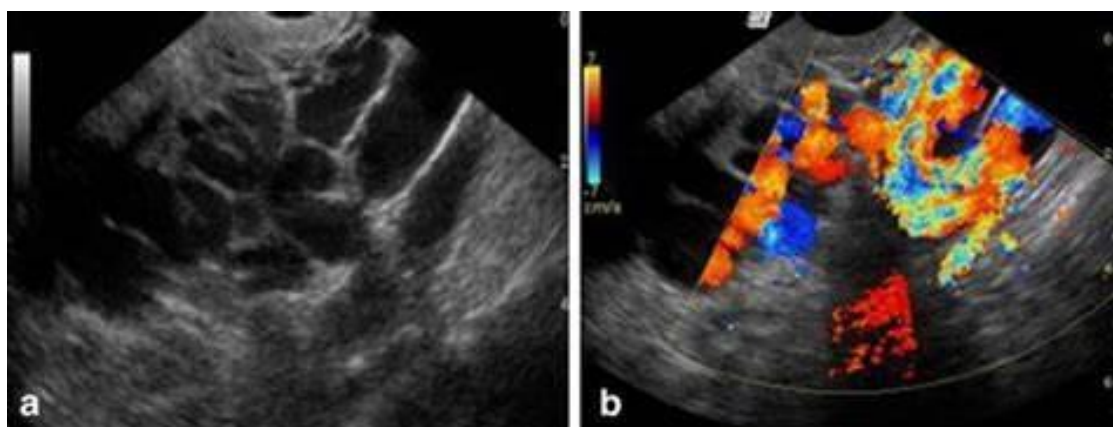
Dilated tortuous veins surrounding on TVUS of left ovary on B-mode (a) and Color Doppler (b) (30)
